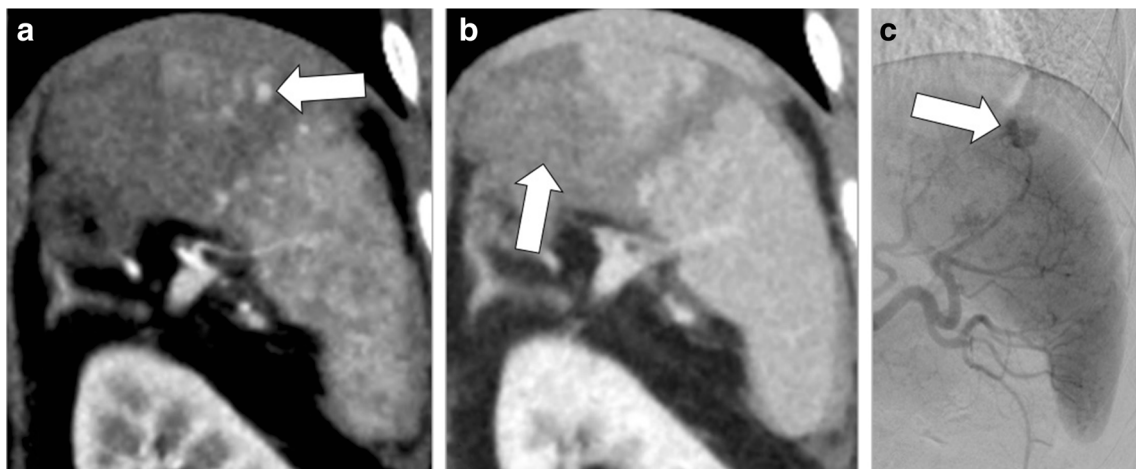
Non-bleeding vascular injury of the spleen. a–c Coronal contrast-enhanced late arterial phase CT (a) demonstrates focal rounded contrast collection within the splenic parenchyma, in keeping with non-bleeding vascular injury. Portal venous phase CT obtained contemporaneously (b)
